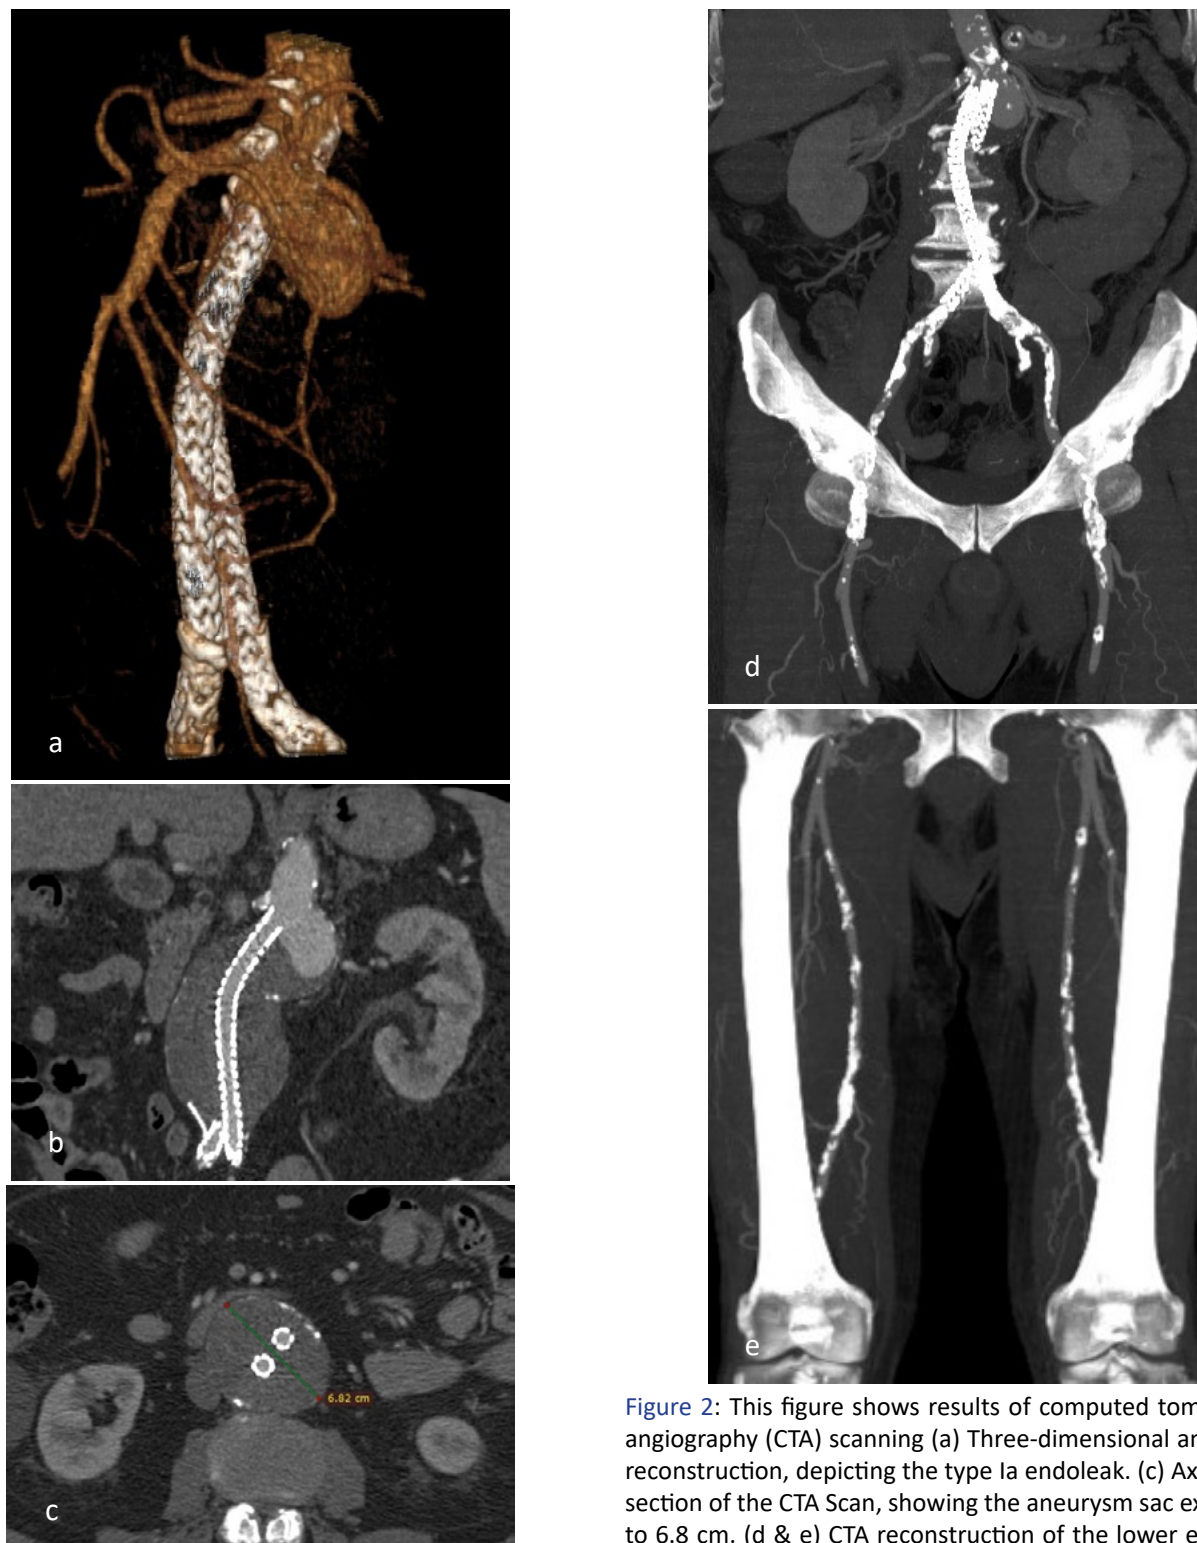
This figure shows results of computed tomography angiography (CTA) scanning (a) Three-dimensional and (b) CT reconstruction, depicting the type Ia endoleak. (c) Axial plane section of the CTA Scan, showing the aneurysm sac expansion to 6.8 cm. (d & e) CTA reconstruction of the lower extremity runoff revealed severe atherosclerotic lesions of the iliac and femoral axes.
